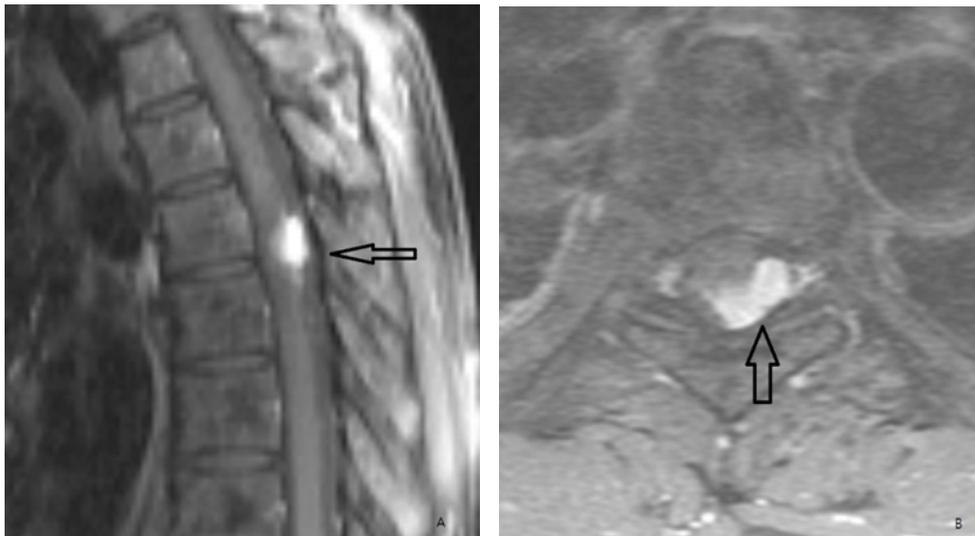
Preoperative sagittal T1-weighted magnetic resonance imaging with contrast enhancement shows a well-enhanced mass displacing the cord anteriorly (A). An axial magnetic resonance image shows the homogeneously enhanced mass displacing the cord anteriorly and to the right (B).
